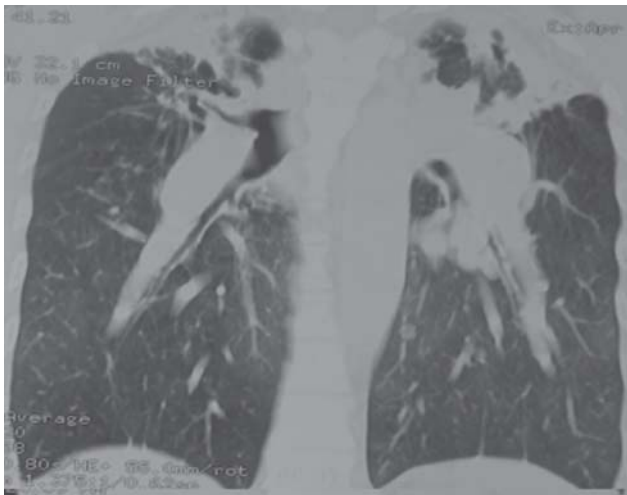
Contrast-enhanced computed tomography of thorax (sagittal section) showing bilateral upper zone pleuroparenchymal fibrosis along with pulled up hila and dilated pulmonary arteries.
